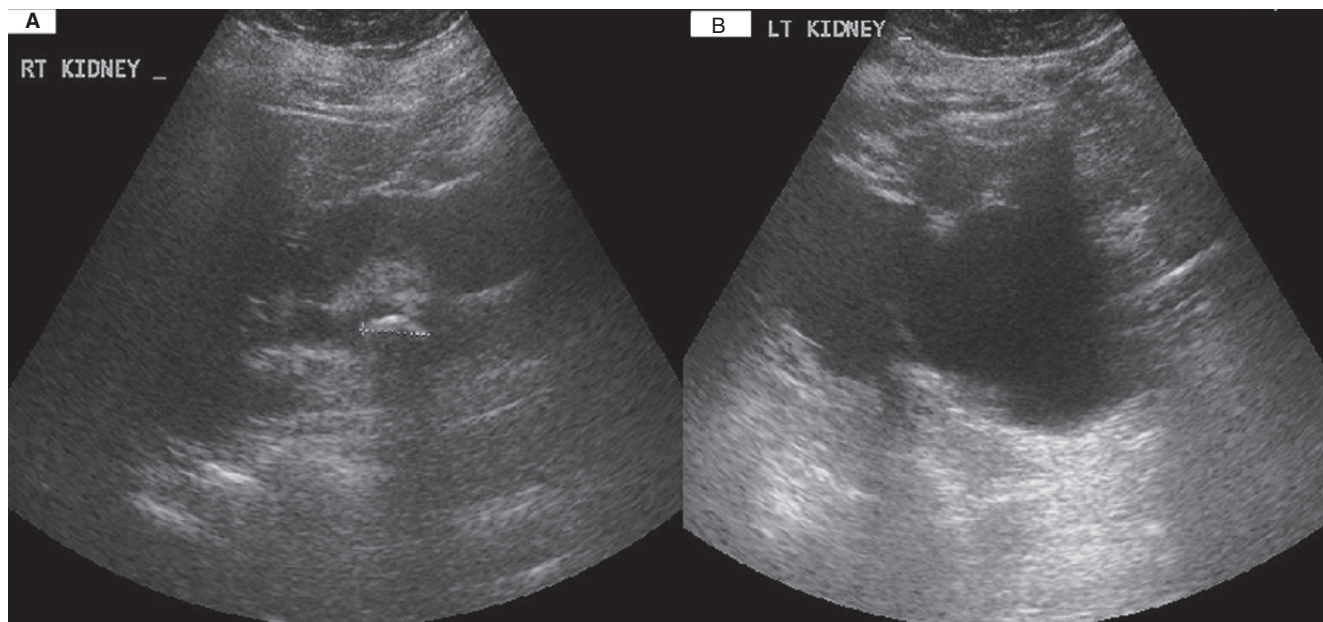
Grayscale ultrasound. (a) Mild hydronephrosis of the right kidney with stone renal pelvis of 2 cm in diameter. (b) Marked hydronephrosis of the left kidney with thinned parenchyma with non-dilated ureter
